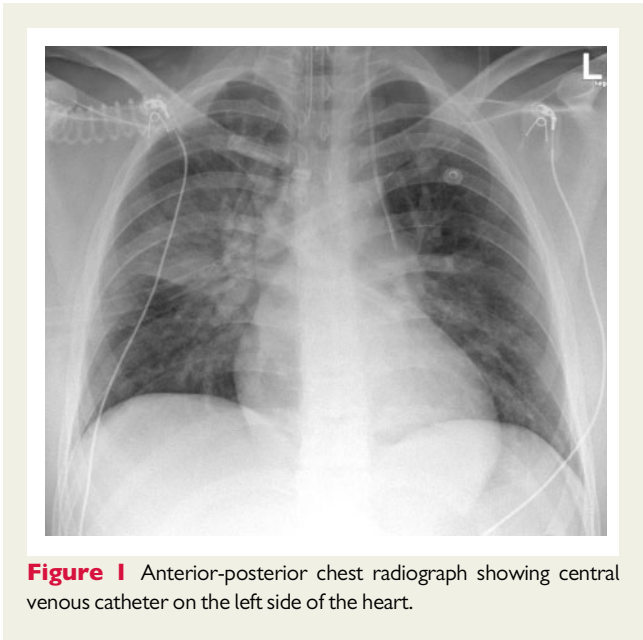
Anterior-posterior chest radiograph showing central venous catheter on the left side of the heart.
